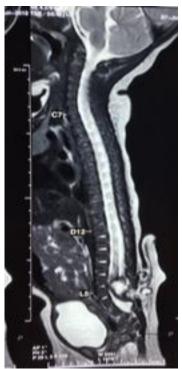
MRI showing pseudotail with dural ectasia
